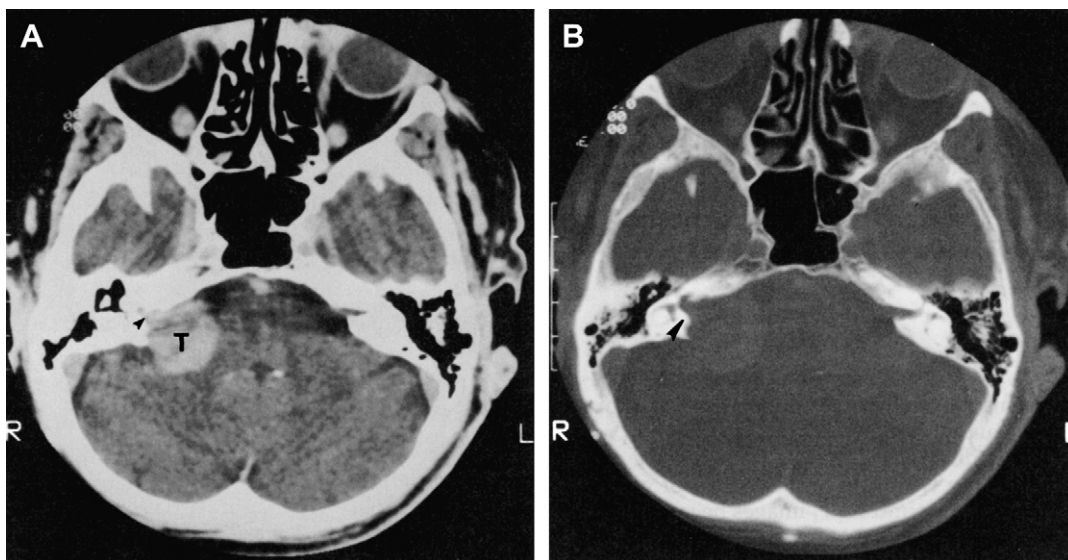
(A) Acoustic neuroma with high resolution computed tomography with contrast. Soft tissue algorithms shows the tumor (T) protruding into the internal auditory canal (IAC) (*arrowhead*). (B) Bone algorithm shows the enlargement of the IAC (*arrowhead*).
